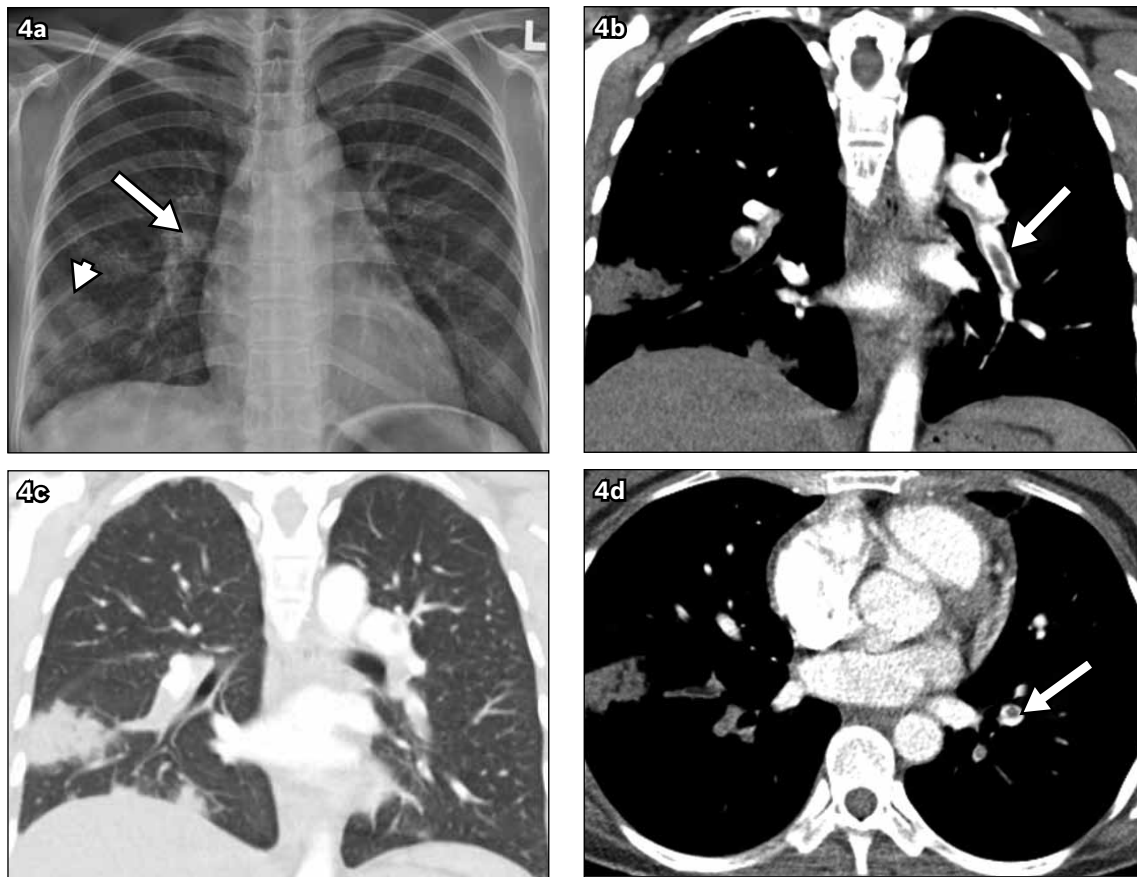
A 34-year-old woman with known antiphospholipid syndrome presented with right-sided chest pain and haemoptysis. (a) Chest radiograph shows a right lower zone peripheral opacity representing a Hampton's hump (arrowhead). Palla's sign (arrow) is also present. (b) Coronal CTPA image (mediastinal window) shows a thrombus in the right lower lobe segmental artery, enlarging its lumen, with pleural-based lung infarct. The left lower lobe segmental artery shows the characteristic 'tram-track' sign (arrowhead) due to the thrombus being surrounded by the contrast-filled artery lumen. (c) Coronal CTPA image (lung window) taken at the same level as the image in Fig. 4b better shows the right pleural-based lung infarct. (d) Axial CTPA image (mediastinal window) shows thrombi within the lower lobe segmental branches bilaterally, and the right pleural-based lung infarct. The left lower lobe segmental branch shows the characteristic 'polo-mint' sign (arrowhead).
